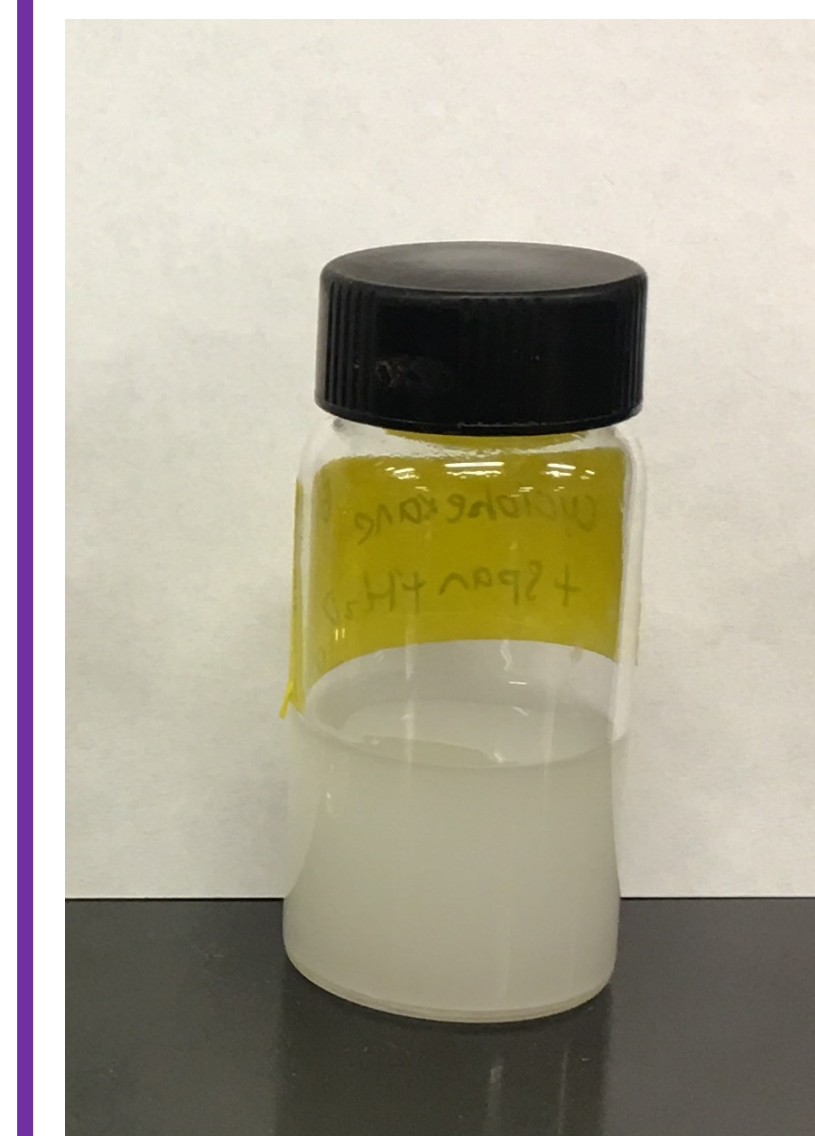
Four-arm poly(ethyleneglycol) tetrabicyclononyne and two-arm poly(ethyleneglycol) diazide were reacted in the aqueous phase under ultrasonication. The crosslinking between the functional groups gave rise to the nanogels.
